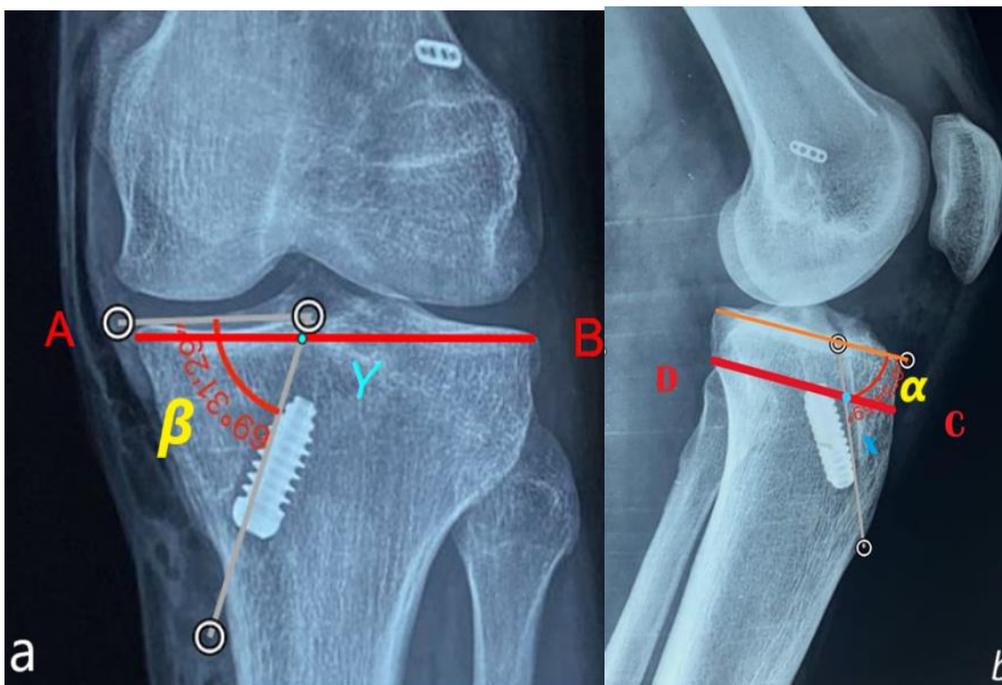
(a): Showing Antero-Posterior X-Ray of knee with widest portion of Tibial Plateau (AB) and point of intersection of mid point of tunnel width in AP view with AB (X). Coronal position of Tunnel = $AY/AB * 100$. β representing tibial tunnel angle in coronal plane.
